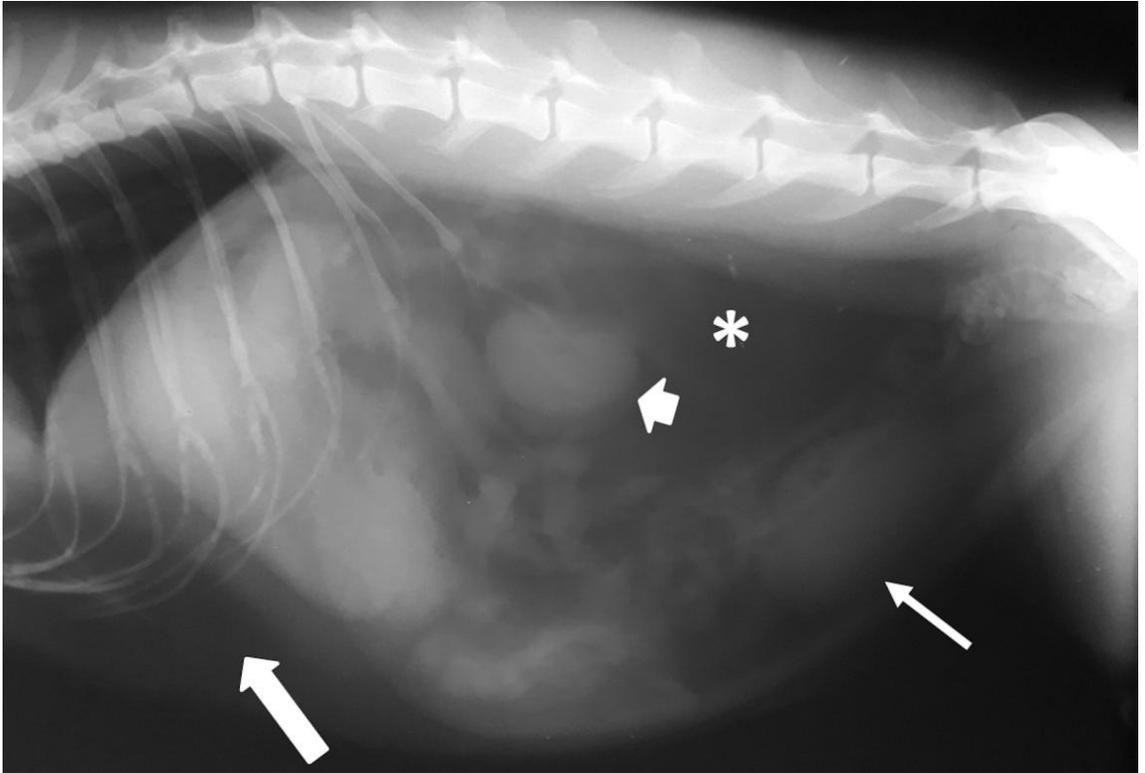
Right lateral (RL) abdominal radiograph of caracal II (14.8 kg; 8.8 yrs). The lumbar spine is almost straight with seven vertebrae. Accumulation of large amount of fat is seen in the cranioventral abdomen ventral to the liver (long thick arrow) and in the retroperitoneal space (*). Note the bunching of small intestines in the central abdomen. The kidneys and urinary bladder are indicated by a short thick arrow and a thin arrow, respectively.
